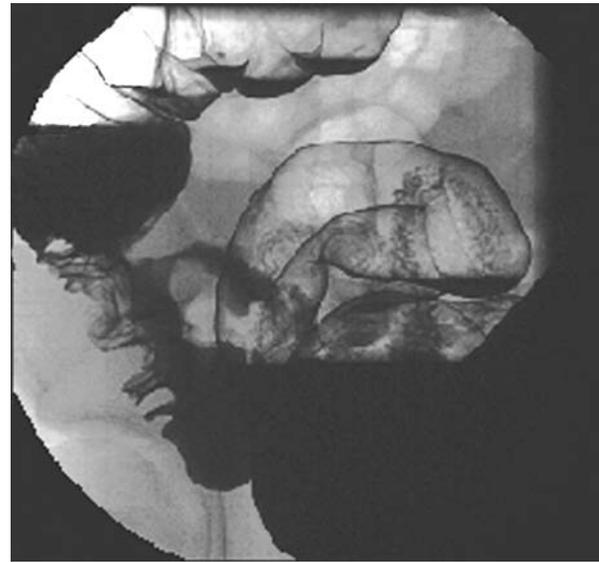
Barium contrast enema radiography
